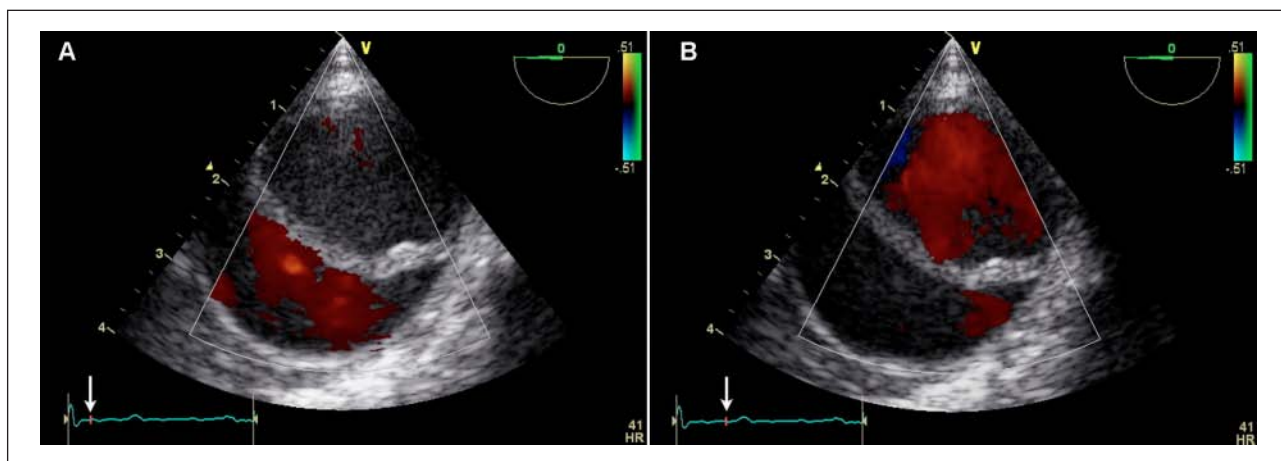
Transesophageal echocardiography short-axis view of a thoracic aortic dissection demonstrating the differentiation of the true lumen versus the false lumen by color flow Doppler evaluation
